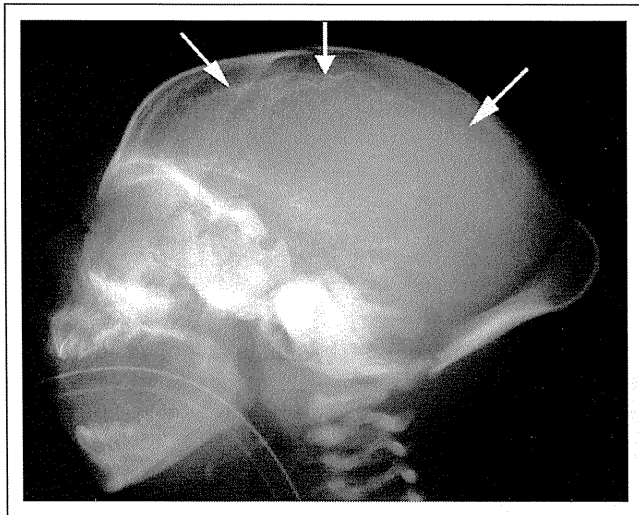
A plain radiograph of the head shows the cranial vault with a frontal sloping and a marked external occipital protuberance. Intracranial high-density spots are visible along the cerebral wall (arrows).
